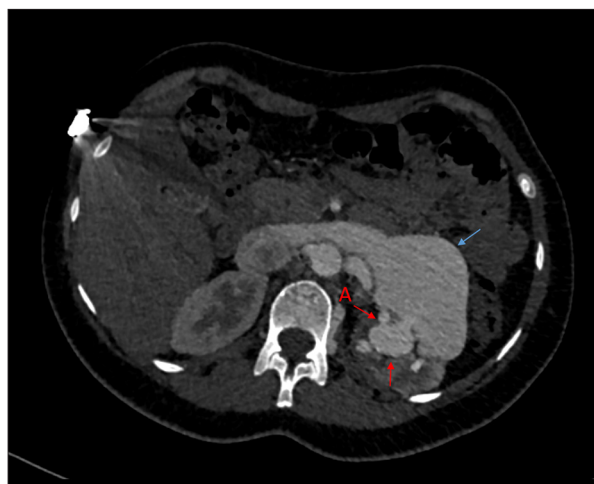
Computed tomography angiogram of the left kidney; axial view of the artery (red arrow A) approaching the nidus (red arrow) with abnormal connection to the large draining vein (blue arrow).
